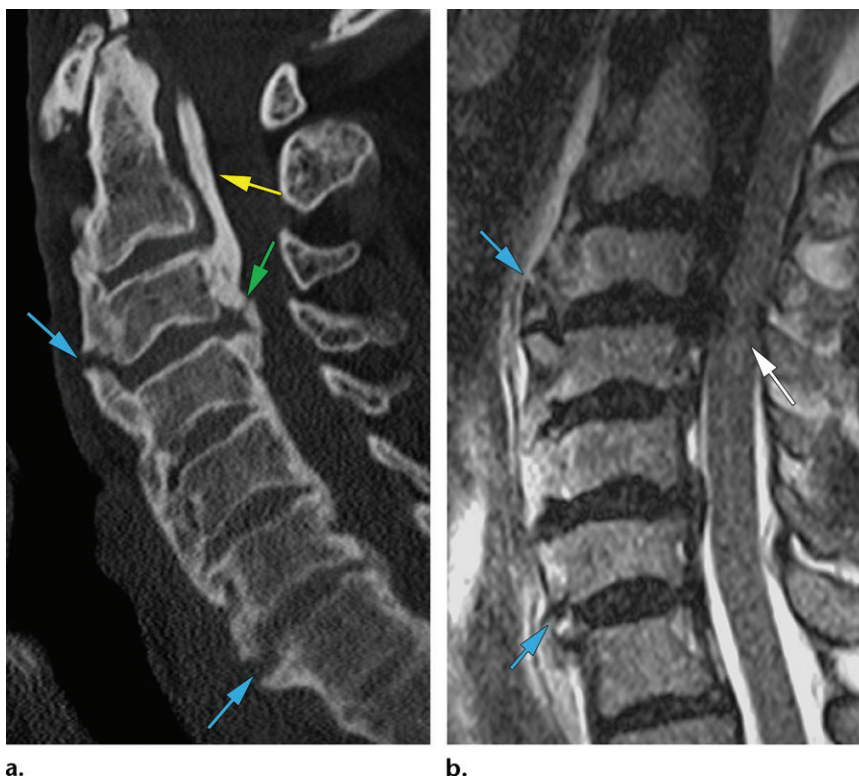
Diagnostic delay in a 69-year-old man with DISH who fell onto his face while walking and immediately noted weakness in his arms and legs with normal sensation. C-spine CT images obtained at an outside hospital (not shown) were interpreted as negative, so the patient was cleared from wearing a neck collar. Because he remained quadriplegic, he was transferred to our institution. Repeat C-spine CT was performed and also indicated no fracture. (a) Sagittal CT image shows areas of discontinuity in the anterior osteophytes (blue arrows) and posterior C3-C4 osteophyte (green arrow), as well as ossification of the posterior longitudinal ligament (yellow arrow). MRI was performed owing to the patient's neurologic symptoms. (b) Sagittal T2-weighted MR image shows acute fractures (blue arrows) of the anterior osteophytes at C3-C4 and C6-C7 with surrounding marrow edema, as well as severe central canal stenosis at C3-C4 with cord contusion (white arrow). These imaging findings support the clinical diagnosis of central cord syndrome. The discontinuity at the posterior C3-C4 osteophyte is not well depicted at MRI but was also diagnosed as an acute fracture.
